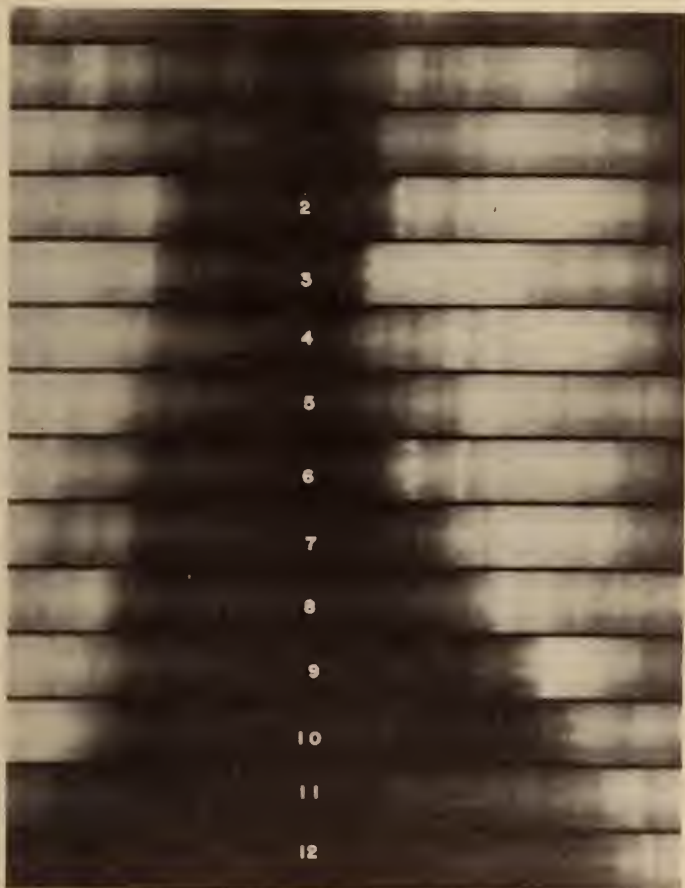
(Case 1). Roentgenkymogram shows distinct lateral systolic movement over the left ventricular contour, well-defined in intervals #9 and #10.
